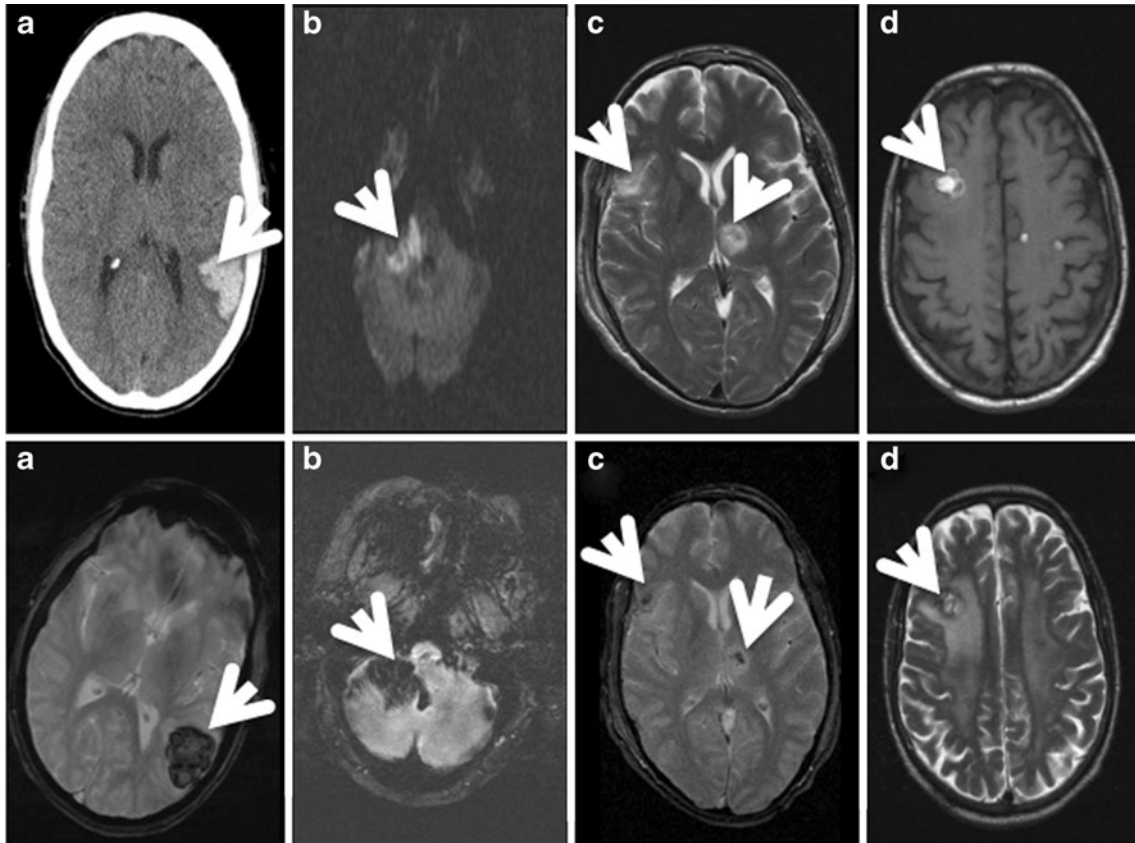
Causes of secondary intraparenchymal hemorrhage (arrows). (a) Lobar hemorrhage (CT and GRE), (b) hemorrhagic infarction [diffusion weighted imaging (DWI) and GRE], (c) traumatic intraparenchymal hemorrhage [T2-weighted MRI (T2WI) and GRE], (d) intratumoral hemorrhage (postcontrast T1WI and T2WI). (High resolution version of this image is available in the [electronic supplementary material](#).)
